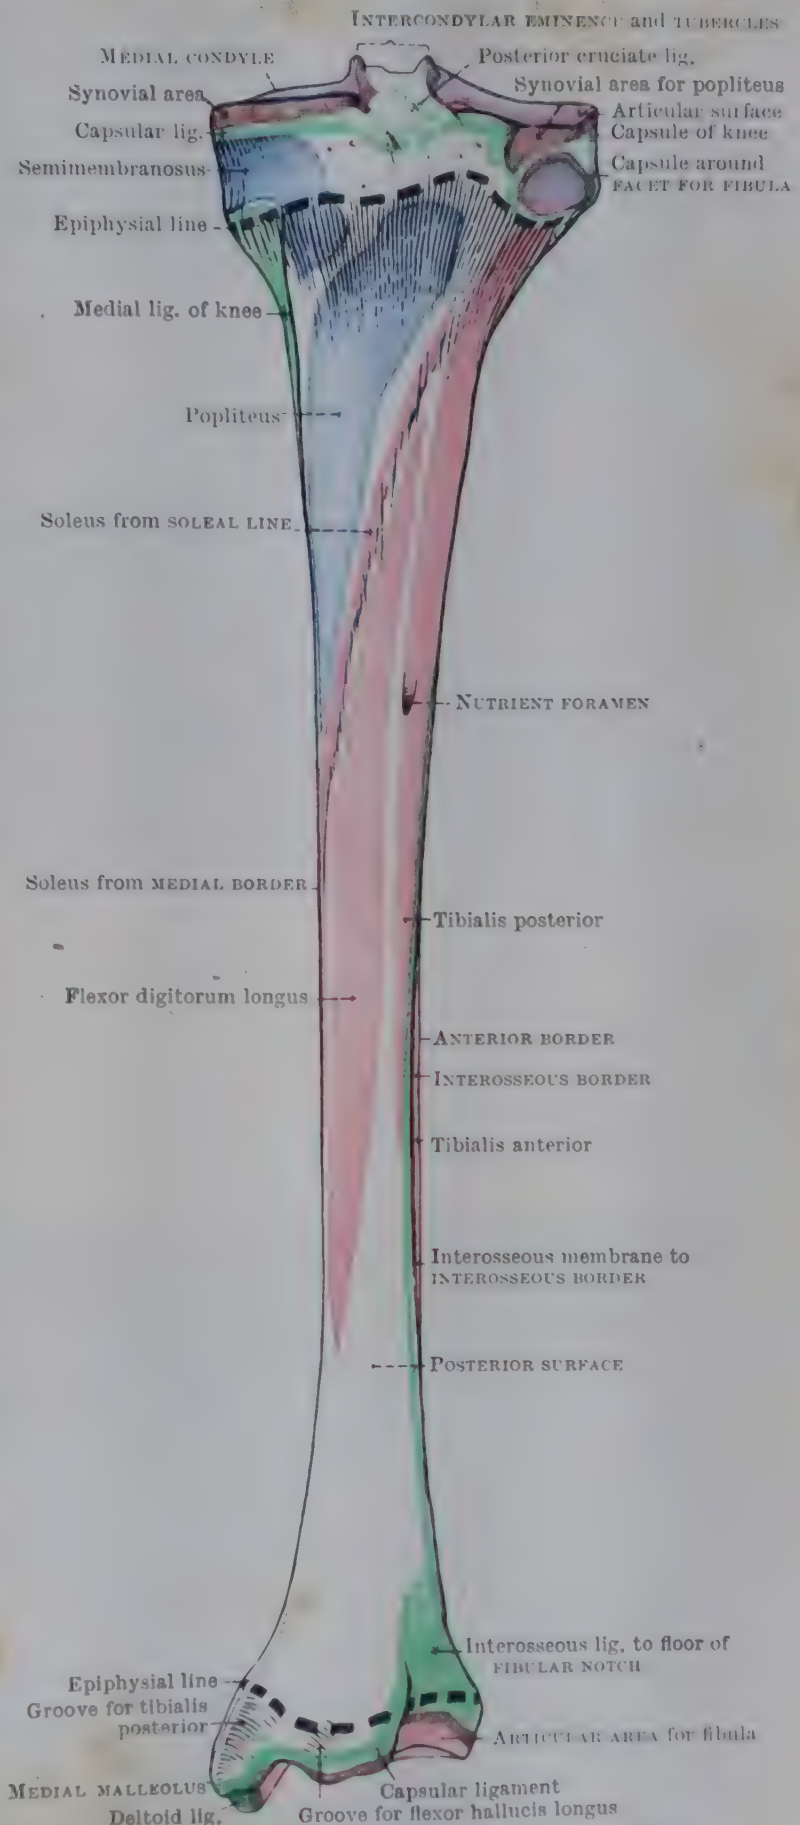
POSTERIOR ASPECT OF RIGHT TIBIA.
